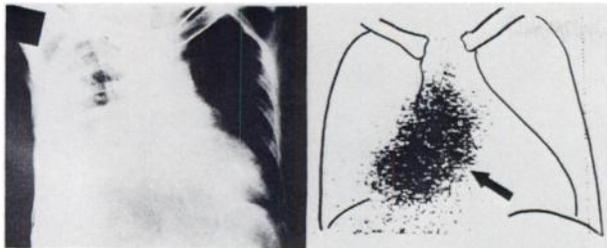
Case 1. Pulmonary carcinoma. Chest x-ray shows mass extending from right hilar region with atelectasis of right lower lobe. Scintigram taken 48 hr after administration of 2.0 mCi of ^{67}Ga -citrate reveals considerable uptake corresponding to shadow in chest x-ray (indicated by arrow). Location and size of tumor are more easily detectable on ^{67}Ga -citrate scan than on chest x-ray.
